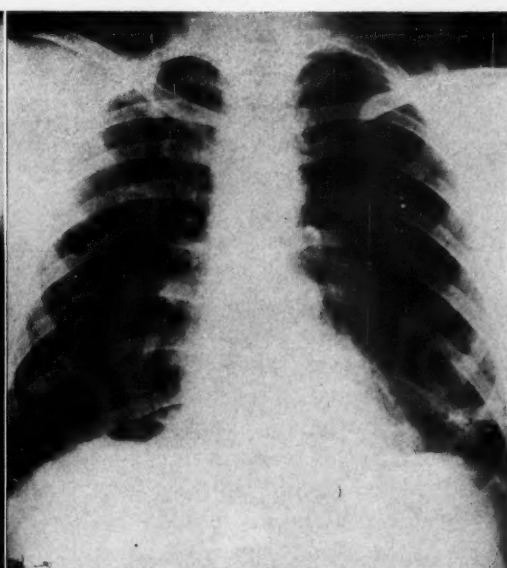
Case 11. Roentgenogram of chest; full inspiration.
